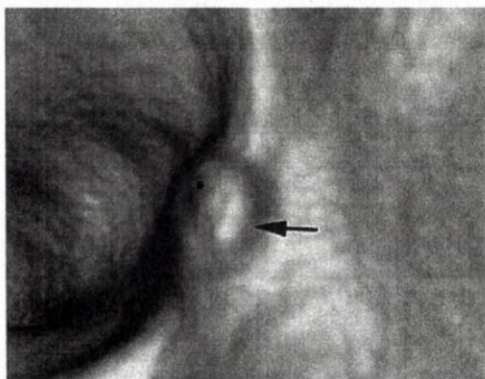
3D endoluminal CT colonographic image demonstrating a CAD mark (red dot) on an 11-mm transverse colonic T1 cancer (arrow)
